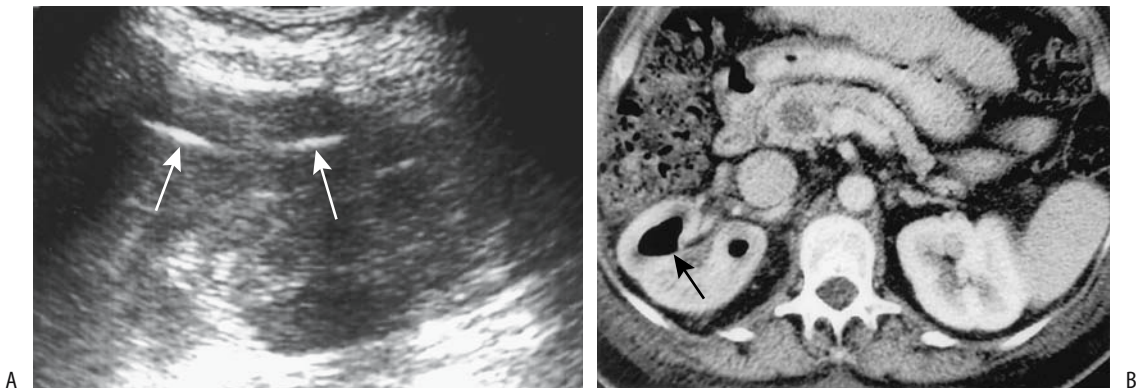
Emphysematous pyelitis. A: Ultrasonography in a woman with cirrhosis and portal hypertension reveals hyperechoic structures with distal shadowing (arrows) in the right kidney. B: Transverse postcontrast CT identifies a gas-fluid level in a dilated calyx (arrow). Follow-up CT 3 weeks after therapy revealed a normal appearing right kidney. (Source: Roy C, Pflieger DD, Tuchmann C, Lang HH, Saussine CC, Jacqmin D. Emphysematous pyelitis: findings in five patients. *Radiology* 2001;218:647–650, with permission from the Radiological Society of North America.)
